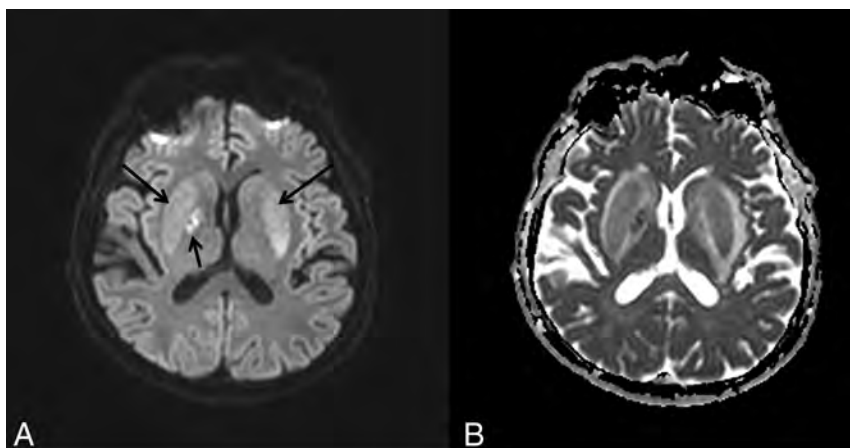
A 67-year-old man (patient 5) presented with unsteadiness. DWI (A) and an ADC map (B) show diffuse mildly increased SI (*long arrows*) in the whole bilateral basal ganglia lesion on DWI with focal restricted diffusion (*short arrow*), corresponding to cytotoxic edema in the right globus pallidus.
